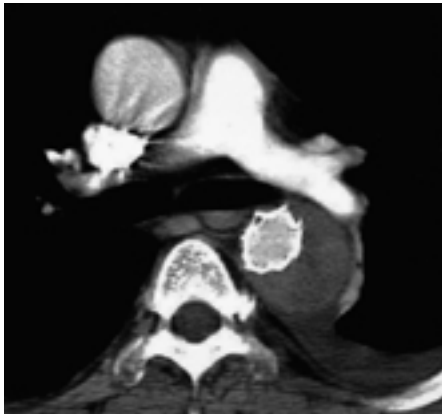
C, D. On follow-up CT scan a week after stent-graft treatment, thrombus formation was noted at the false lumen of descending thoracic aorta. Thrombus was not formed at the infrarenal aorta but the shape of true lumen became convex at the infrarenal aorta.
